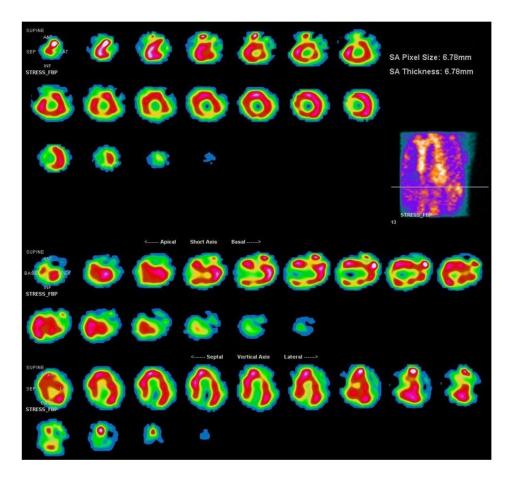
Patient's 1 Cardiac SPECT. Almost the entire area of the left ventricle is clearly seen.
